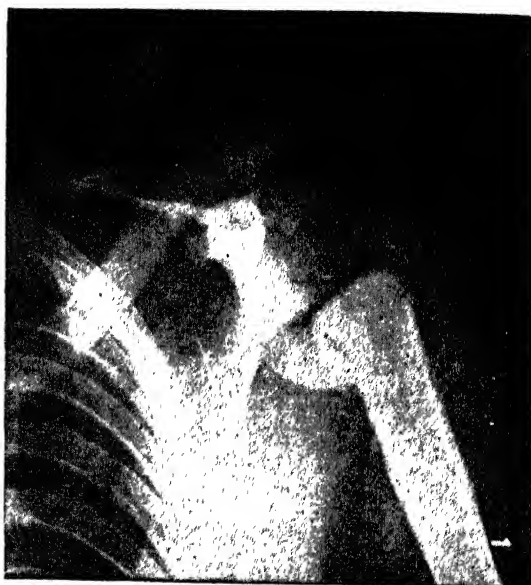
Roentgenogram of left shoulder, July 19, 1943, seventeen months after original examination (Fig. 55); bone destruction in the scapula and humerus is increased only slightly. (Pendergrass, E. P., Gannon, G. D. and Powell, J. H.: *Radiology* 45: 139 (Aug.) 1945.)
